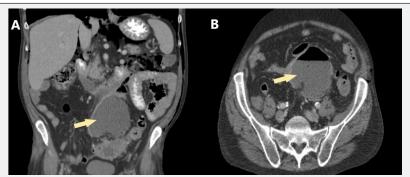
Coronal (A) and axial (B) abdominal CT scan shows an intraabdominal abscess (yellow arrow) and unstructured mesosigmoid due to perforated diverticulitis.
